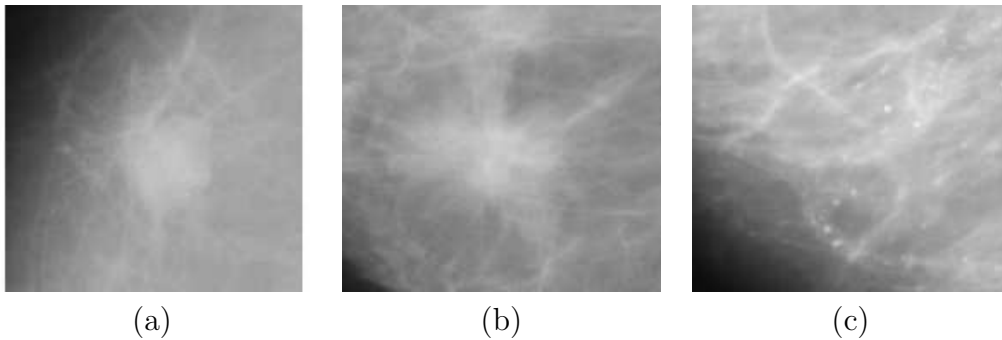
Types of X-ray mammographic lesions: (a) circumscribed and (b) spiculated lesions and (c) microcalcifications.
